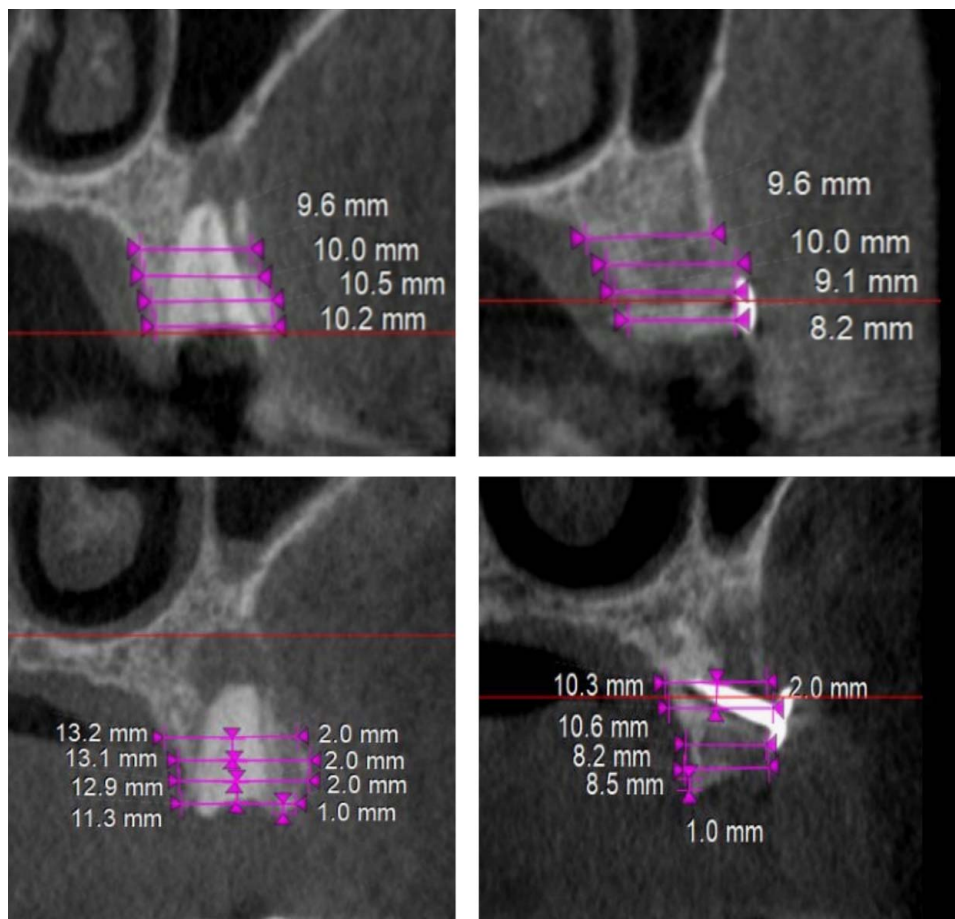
The radiographic measurements of the alveolar ridge width before surgery and after alveolar ridge preservation using tenting screw.
